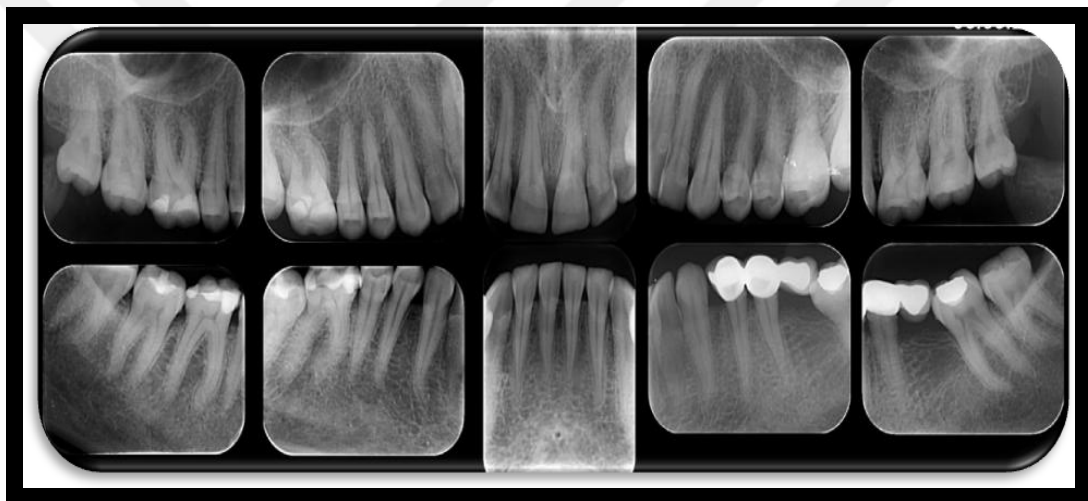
b. Radiographic view
